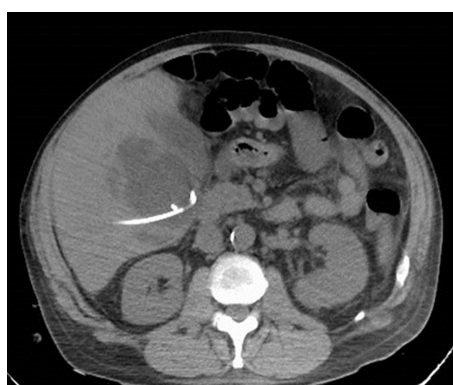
Abdominal computed tomography image showing percutaneous transhepatic drainage of the more superficial, inferior lobe.
